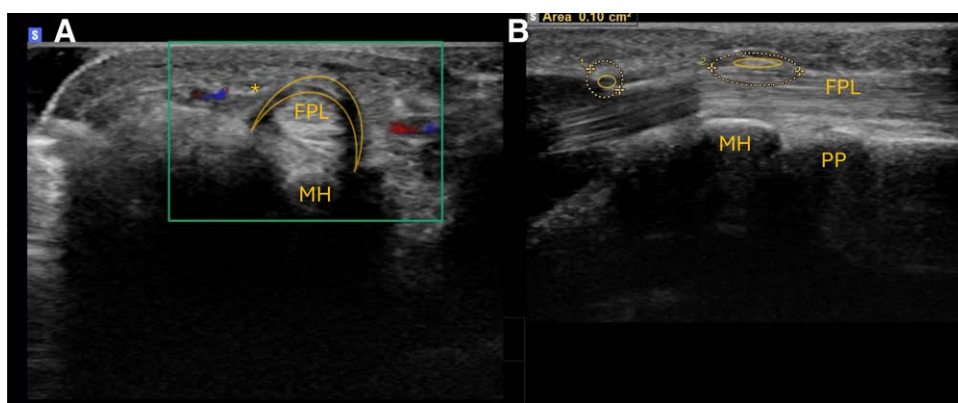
(A) Color Doppler short-axis ultrasound view of flexor pollicis longus tendon (FPL) and A1 pulley with radial digital nerve and radial and ulnar neurovascular bundles. (B) Long-axis view of A1 pulley distally and radial digital nerve crossing over FPL proximally. Flexor pollicis longus tendon (FPL), radial digital nerve (small oval overlay), A1 pulley (crescent in (A) and oval overlay in Fig. 3B), proximal phalanx (PP), and first metacarpal head (MH).
